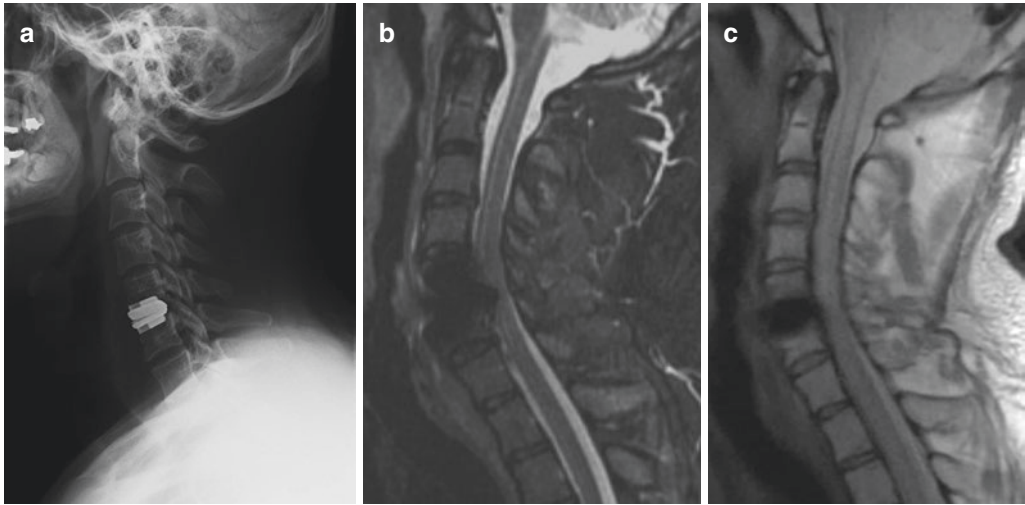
A 36-year-old male with neck pain radiating to the left arm status post C5–6 artificial disc replacement as seen on the lateral radiograph (a). Sagittal T2-weighted conventional MR image (b) demonstrates susceptibility
